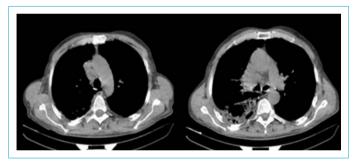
Non-contrast CT: Right paratracheal 25×33 -mm conglomerate lymph node and diffuse consolidation with air bronchograms in the lower right lobe.
